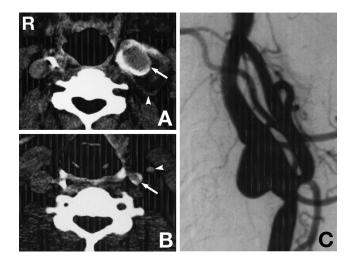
A, B: Computed tomography scans of the neck, (A) obtained at admission showing an aneurysm at the cervical portion of the internal carotid artery (ICA) (arrow), irregular enhancement of the ICA wall with a partial defect, and surrounding hematoma (arrowhead), and (B) after angiography showing marked enhancement of the ICA wall (arrow) but not the external carotid artery wall (arrowhead). C: Left common carotid angiogram showing stenosis of the common carotid artery and the irregularly-shaped aneurysm at the cervical portion of the ICA. The diagnosis was pseudoaneurysm.
